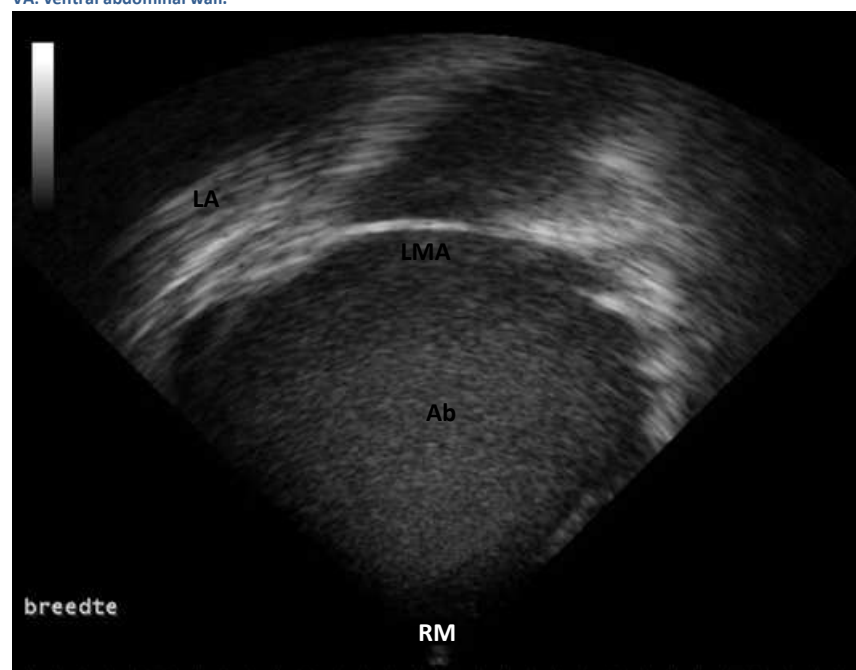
Ultrasonographic image of abomasum, preset: Canine A PA230, Depth: 23 cm. Right lateral measurement of abomasal width. Ab: abomasum, LMA: left margin of abomasum, LA: left lateral abdominal wall, RM: right margin of abomasum.
